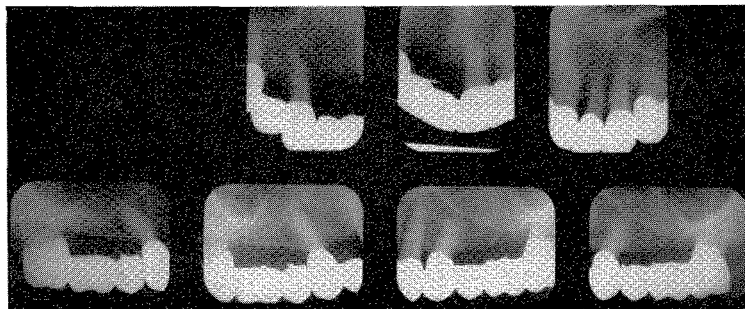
Roentgenograms taken in 1962 of the upper splint shown in Fig. 334.
